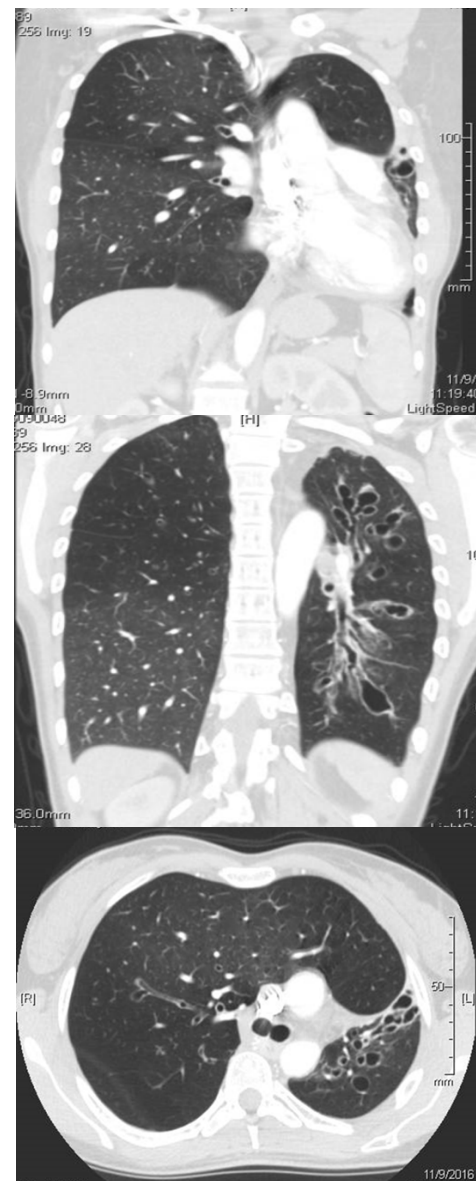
Thoracic CT scan: small hyperlucent left lung with diminished vascularity and large cystic bronchiectasis, compensatory hyperinflated right lung
